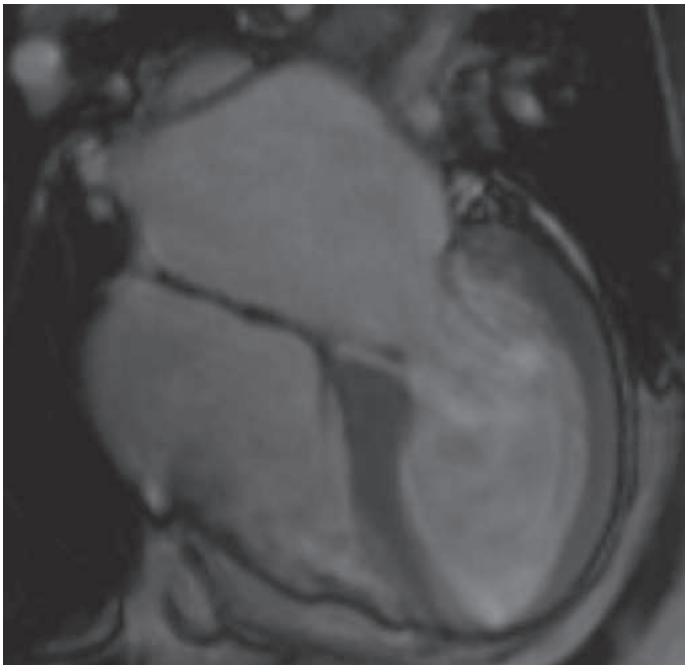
Takotsubo cardiomyopathy. Four-chamber view of cardiac magnetic resonance imaging demonstrating a mildly dilated left ventricle in diastole (left panel) with diffuse hypokinesis of the mid and apical segments and relative sparing of the basal segment wall motion at end systole (right panel) with left ventricular ejection fraction 46%. (Image courtesy of Raymond Kwong, MD, and Zariyat M. Mannan, MD, Cardiovascular Imaging, Brigham and Women's Hospital, Boston.)
